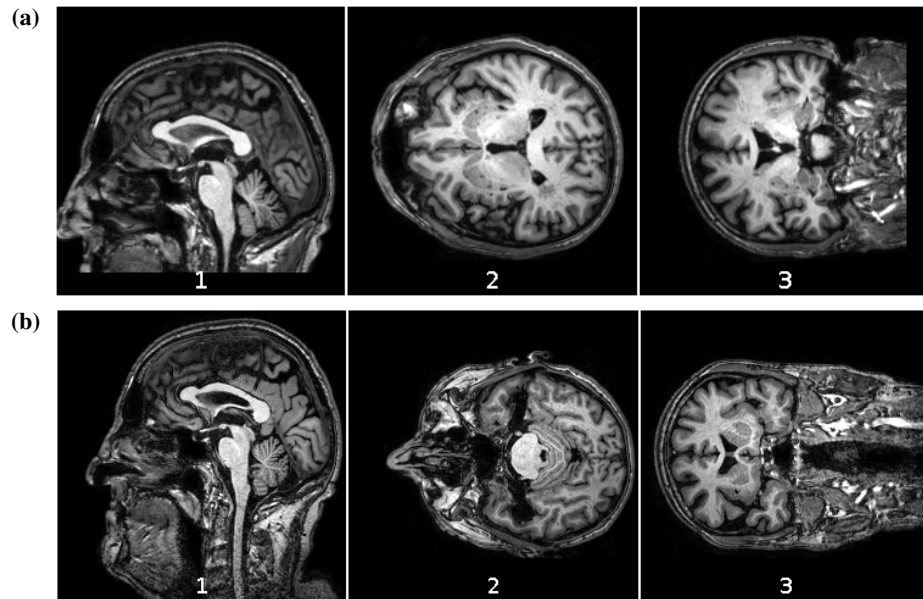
Two triplets of orthogonal central sectioning planes of one adult brain MR image without rotations (i.e. from 1 to 3: sagittal, trasverse and coronal planes). (a) The brain image is aligned to the MNI152 template; (b) the brain image is not aligned to the MNI152 template and as a result original neck tissue is still kept.
